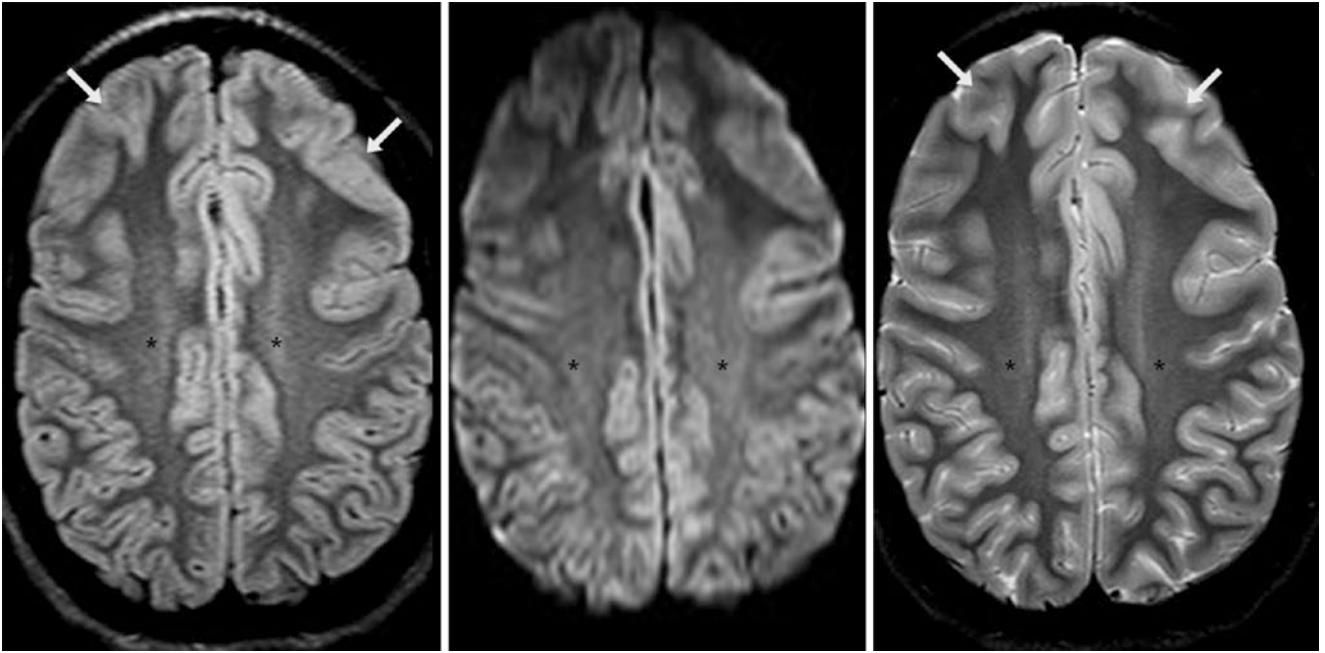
A 19-year-old had concussive symptoms that resolved soon after. A negative 3 T MRI with FLAIR (*left*), DWI (*middle*), and T2WI (*right*) showed normal, subtle hyperintensity of the PVWM bilaterally
